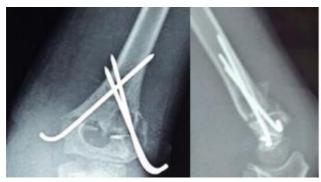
(Original) shows immediate post-operative elbow and wrist joint plain radiographs of the same patient.
